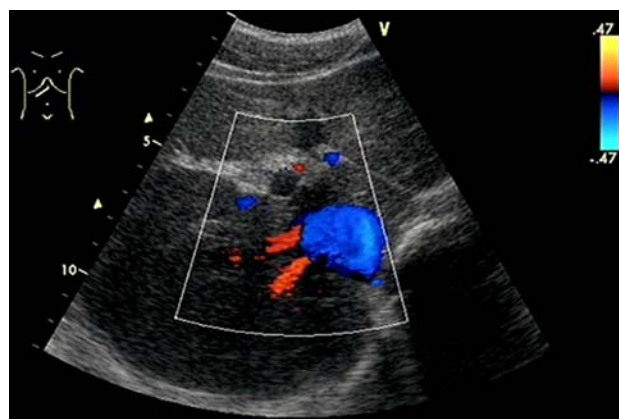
Color Doppler image showing two AHVs
